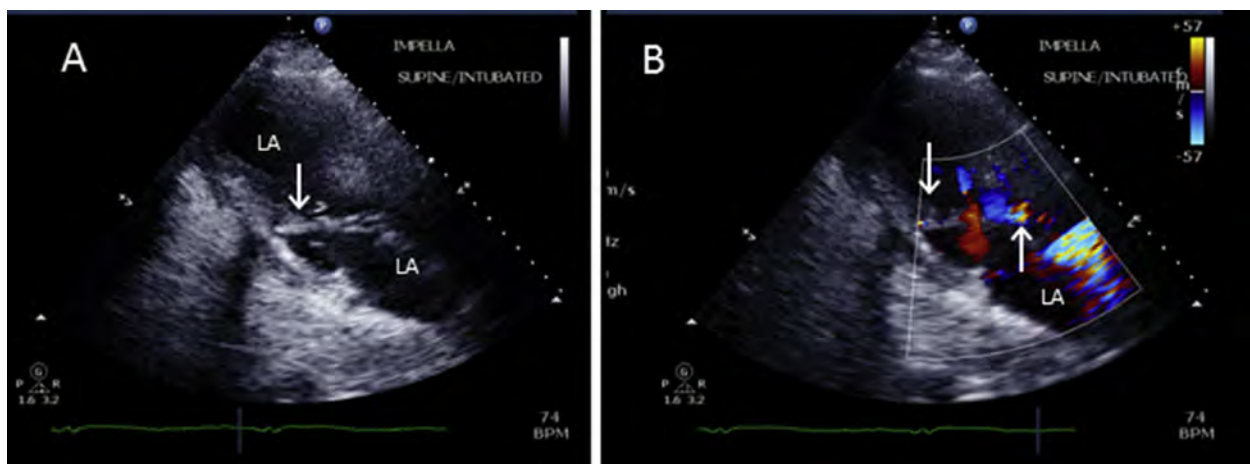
The Impella CP Percutaneous LVAD (A,B), modified TTE parasternal long-axis view, showing the distal pigtail lodged in the submitral apparatus (downward arrow) with the inflow zone (cage) adjacent to the MV anterior leaflet and too close to the aortic annulus (upward arrow, view B).
